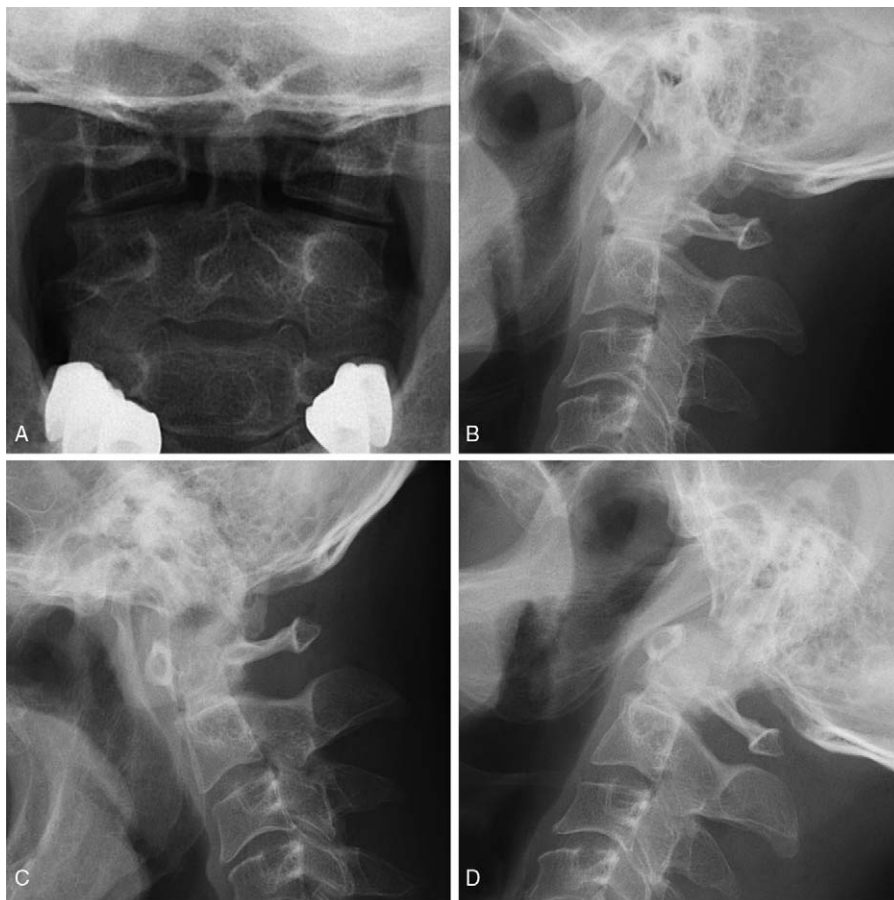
At the 1-year follow-up, solid union was achieved without abnormal motion of C1–2 on plain radiographs including flexion and extension lateral radiographs (A–D).
